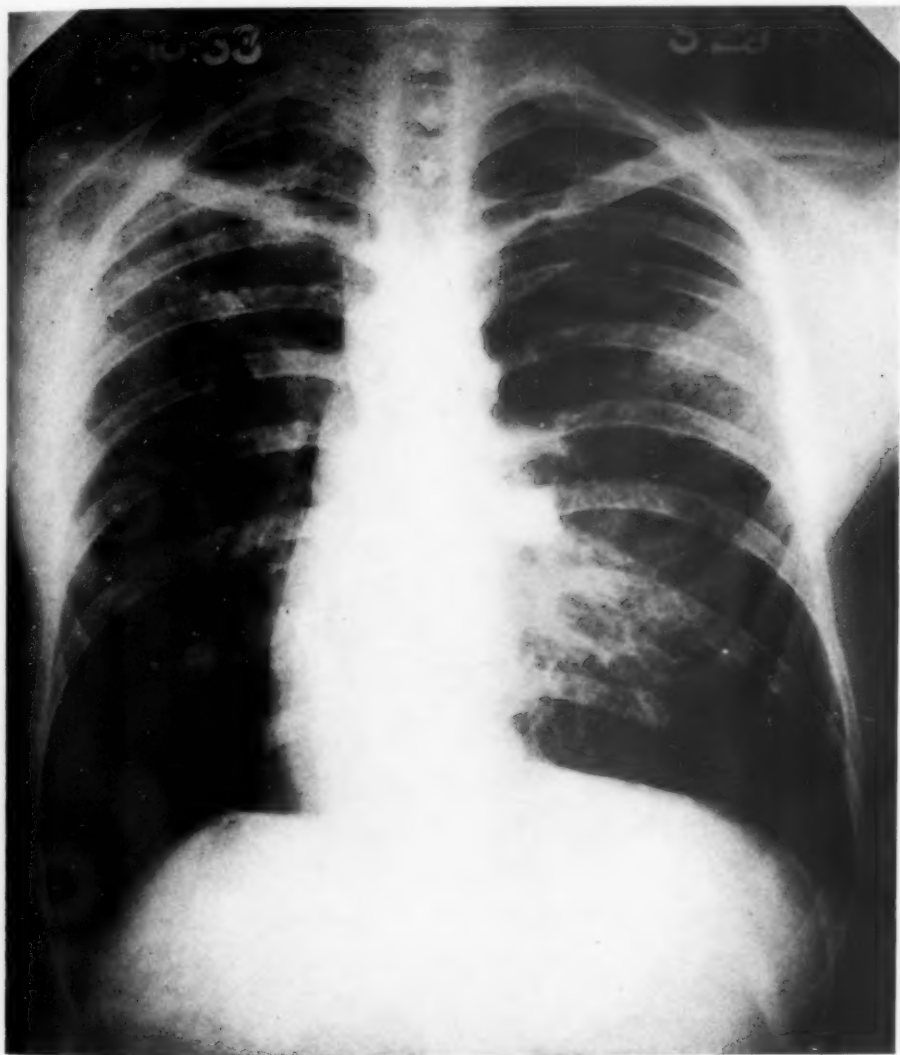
Roentgenogram of chest, February 18, 1933.
